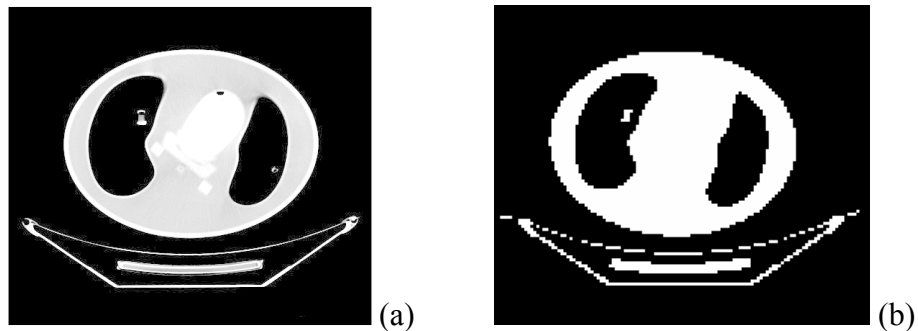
Original CT Slice on the left and Binary CT slice on right
